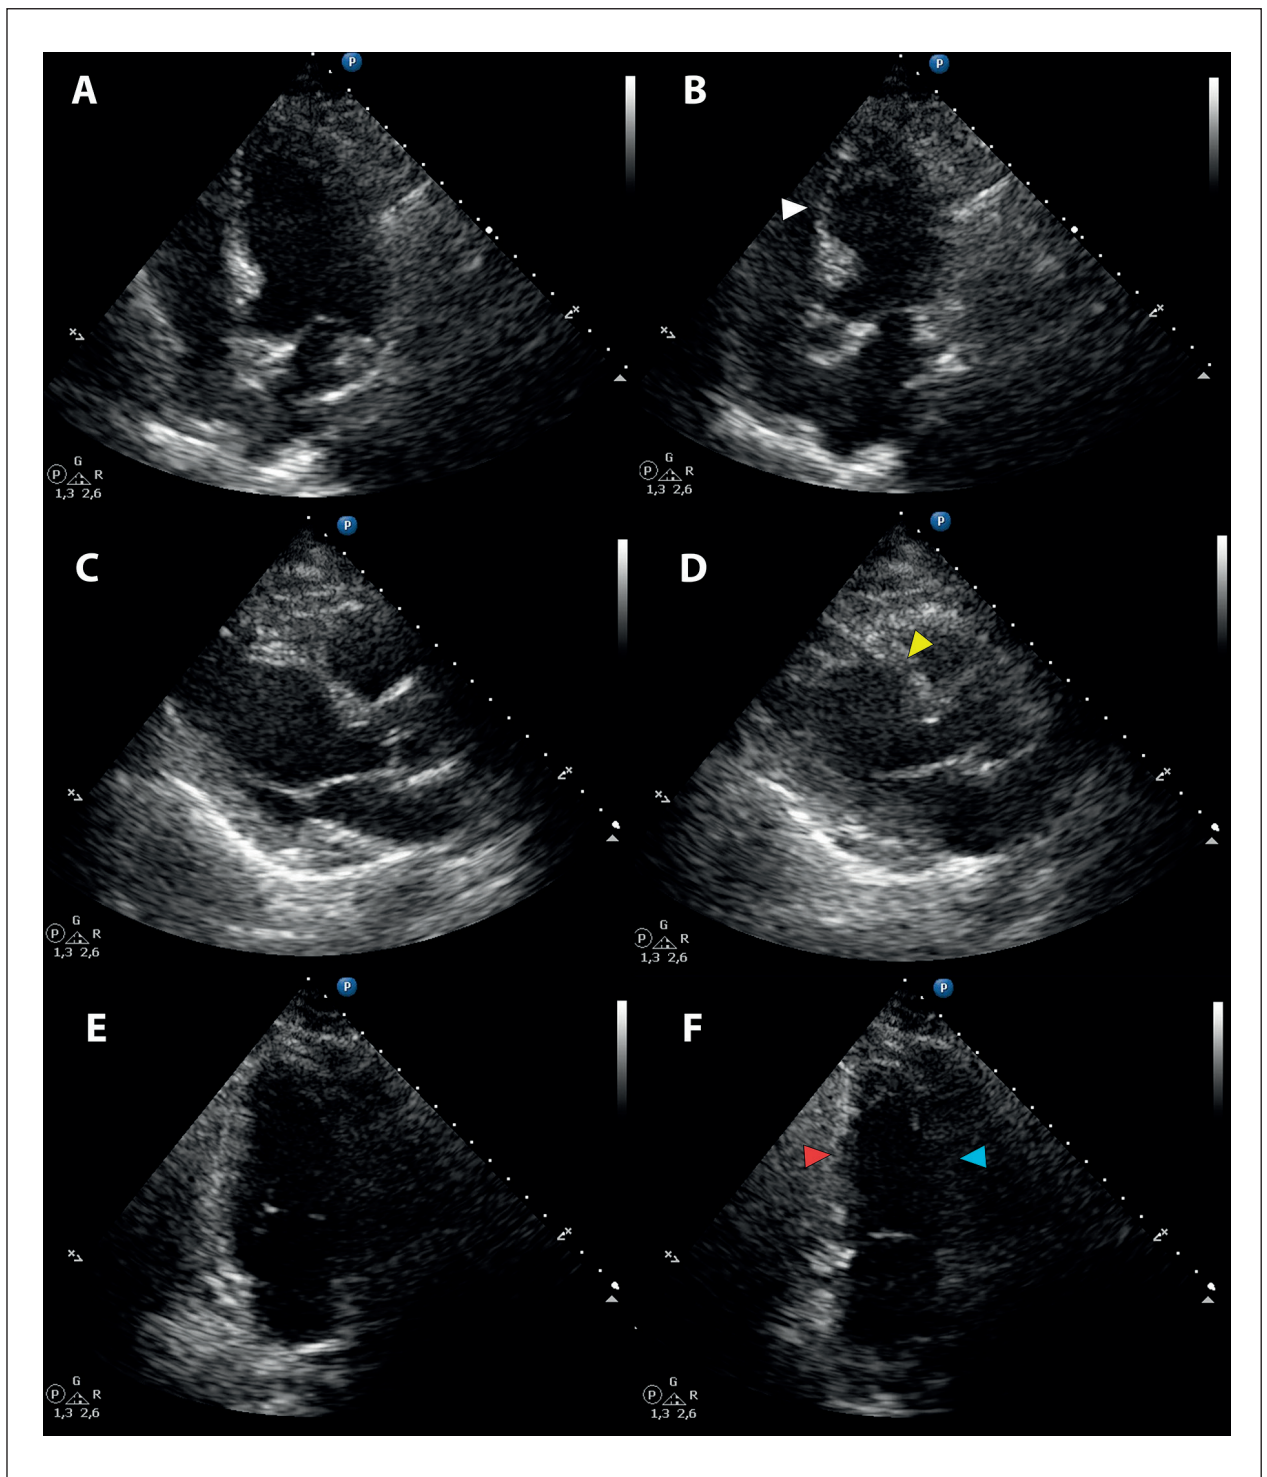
Transthoracic Echocardiogram (TTE) Findings. A-B) TTE Four-chamber view in diastole (A) and systole (B) demonstrating mid inferoseptal segment akinesia and bulging (white arrowhead). C-D) Parasternal long-axis view in diastole (C) and systole (D) demonstrating mid anteroseptal segment akinesia and bulging (yellow arrowhead). E-F) Two-chamber view in diastole (E) and systole (F) demonstrating mid inferior akinesia (red arrowhead) and mid anterior hypokinesia (blue arrowhead). TTE confirmed previous left ventriculography findings, which were suggestive of SCM.
